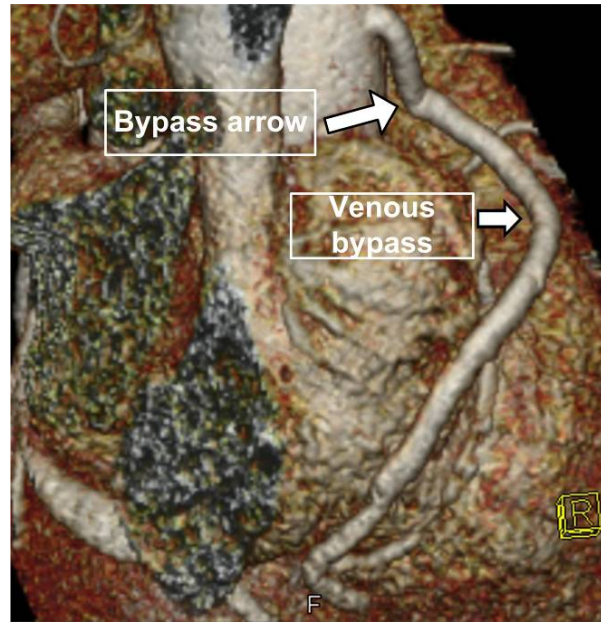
Multidetector computed tomographic (MDCT) angiography in a 44 year old male CABG patient with venous grafts (*arrow*). Three-dimensional reconstruction of the heart and vessels with volume rendering techniques.
